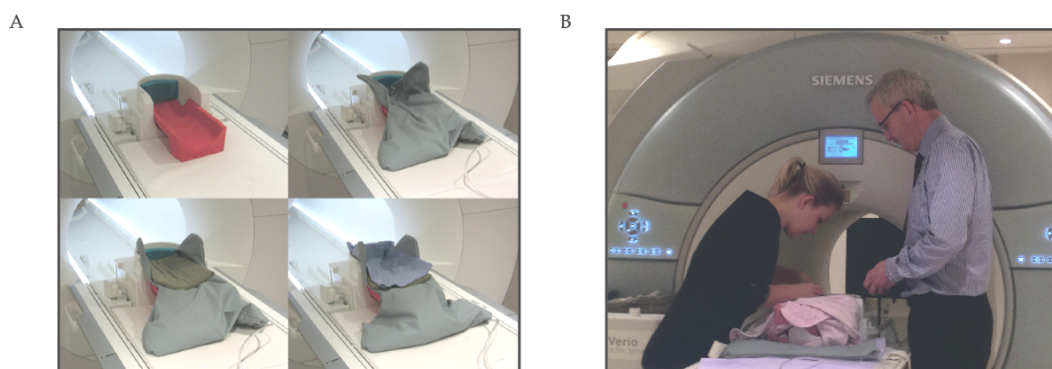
MRI acquisition. A. The custom foam cradle (red) is slotted into the adult 32 channel head coil and overlaid with a vacuum mattress (grey) and soft padding for comfort and to limit upper body and head movements. B. The swaddled infant is placed in the cradle and three-level ear protection is fitting and checked.
